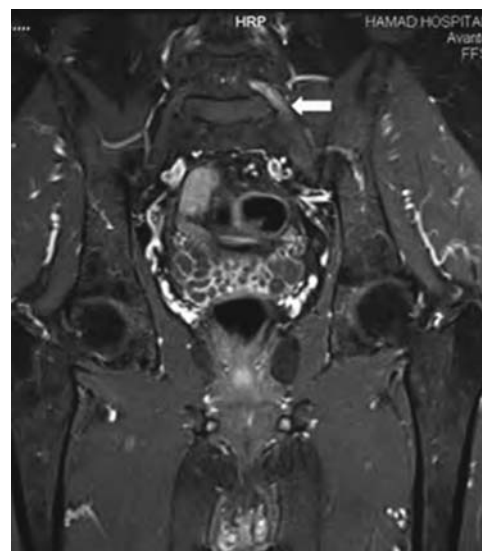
MRI coronal section post gadolinium contrast shows enhancement of the left L5 nerve root (arrow).
